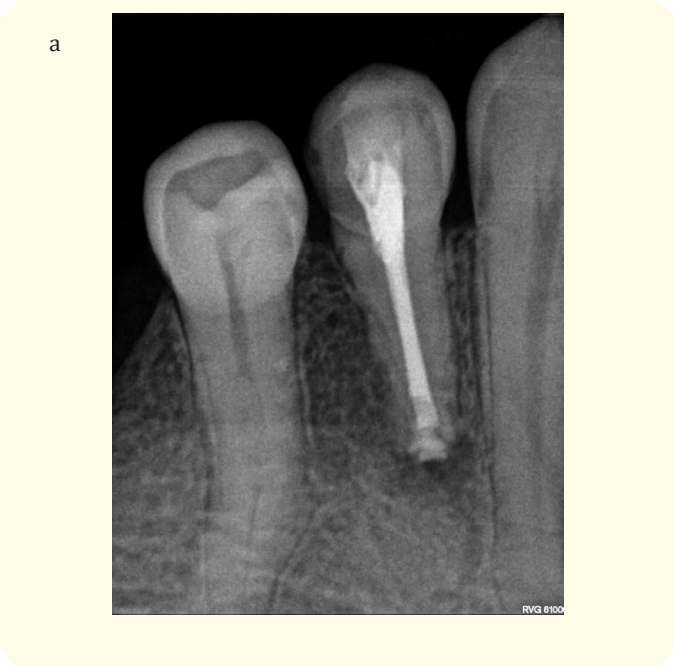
a: Periapical radiograph 2 years after the intervention showing significant bone regeneration.
